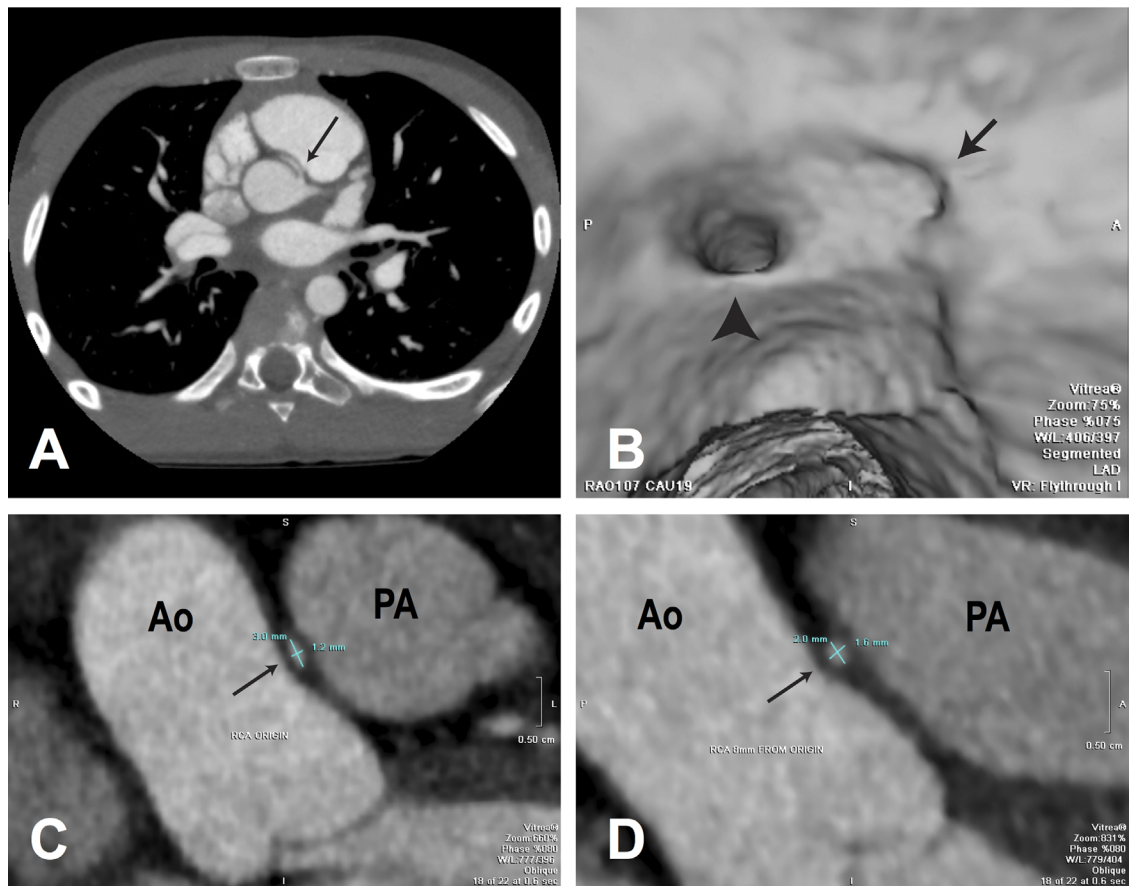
CTA imaging in AAOCA. (A) An ARCA (arrow) arising from the left sinus of Valsalva and traveling intramurally and interarterially. (B) A virtual angiography that demonstrates a normal left coronary ostium (arrowhead) and an abnormal, small, and slitlike ostium of the right coronary (arrow) arising just above and to the left of the intercoronary commissure of the aortic valve. (C and D) A transverse cut of an anomalous right coronary artery (arrow) demonstrates an oval morphology close to its origin (likely due to intramurality) and a normal round morphology 8 mm from its origin. Intramurality is determined by quantification of the density of the tissue around the coronary (presence or absence of pericoronary fat between the coronary and the aorta) and the shape of the coronary artery. Ao, aorta; PA, pulmonary artery; RCA, right coronary artery. © 2014 Texas Children's Hospital (reprinted with permission). (Color version of figure is available online.)
